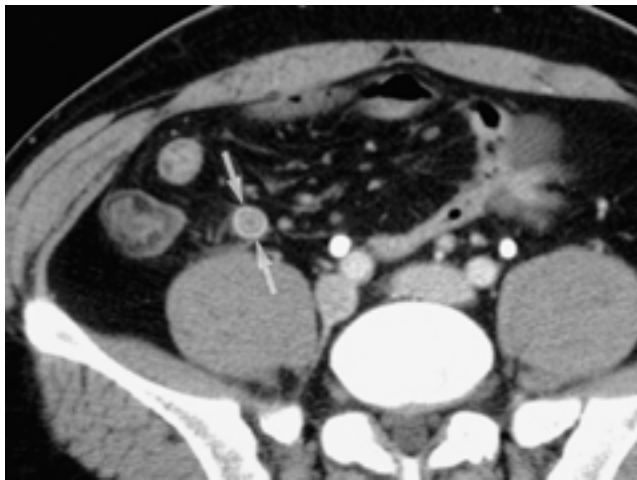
Acute appendicitis in a 35-year-old man. Contrast-enhanced CT scan shows mural stratification enhancement ('target sign') of an inflamed appendix (arrows).
